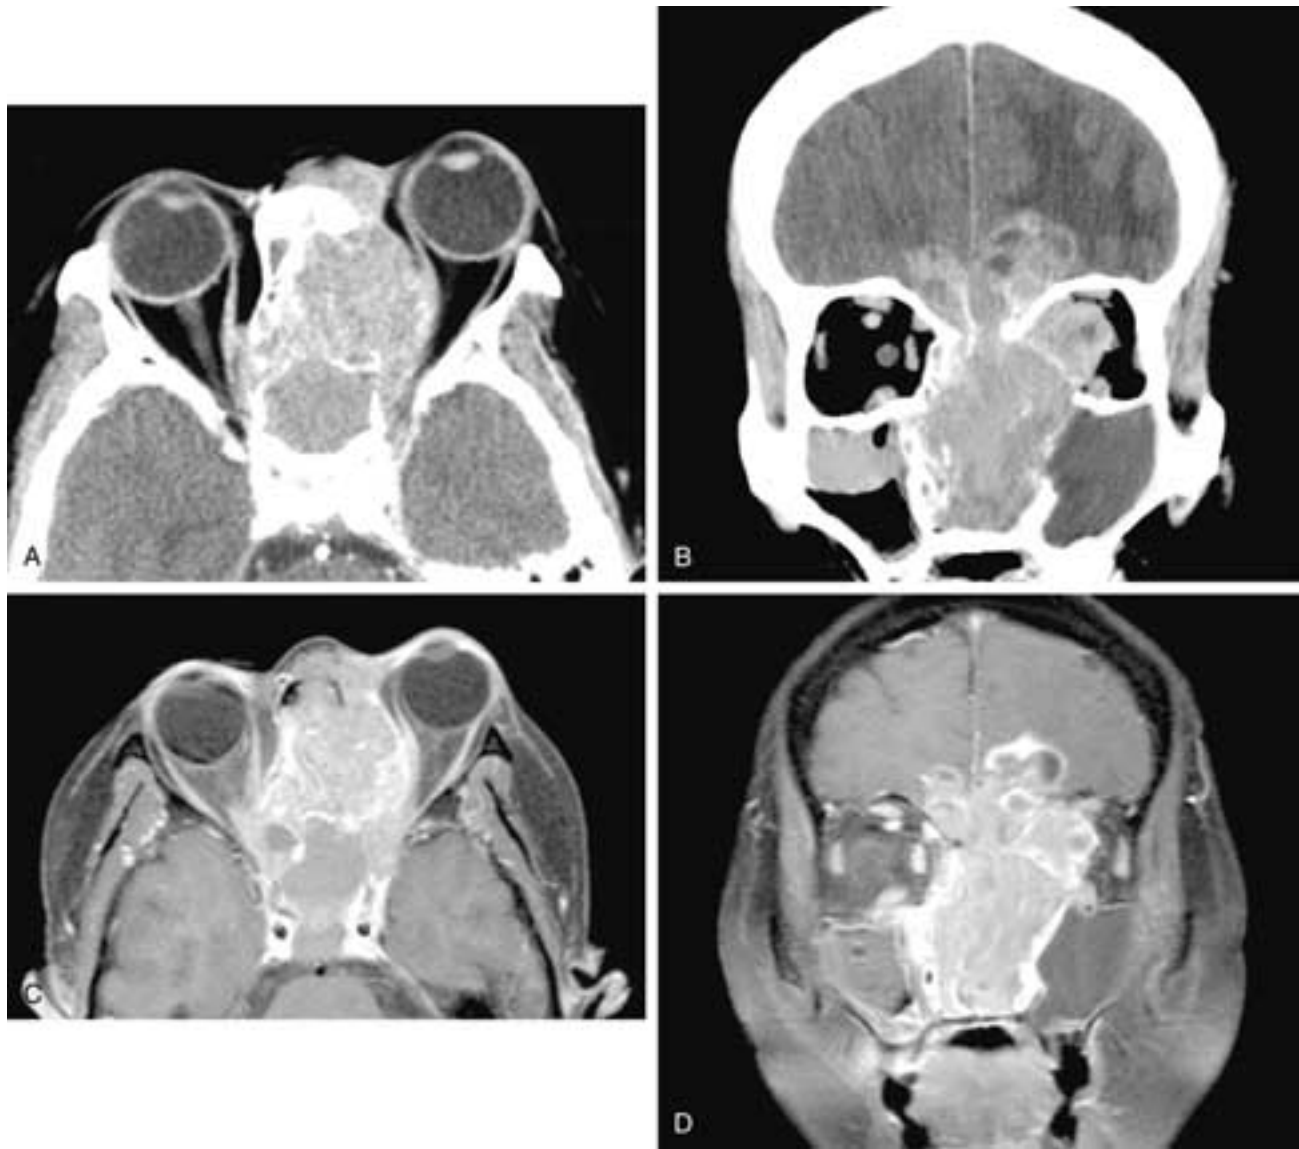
Axial (A) and coronal (B) contrast-enhanced CT scans show a destructive mass that has broken into the anterior cranial fossa and invaded the brain. The tumor also has extended into both orbits and obstructed the left antrum. Incidental inflammatory disease is present in the right maxillary sinus. Axial (C) and coronal (D) T1-weighted, contrast-enhanced MR images confirm the disease mapping and the presence of a sphenoid sinus mucocoele. Statistically, in a 45-year-old male, this imaging appearance should suggest the diagnosis of squamous cell carcinoma. This patient had a rhabdomyosarcoma.
